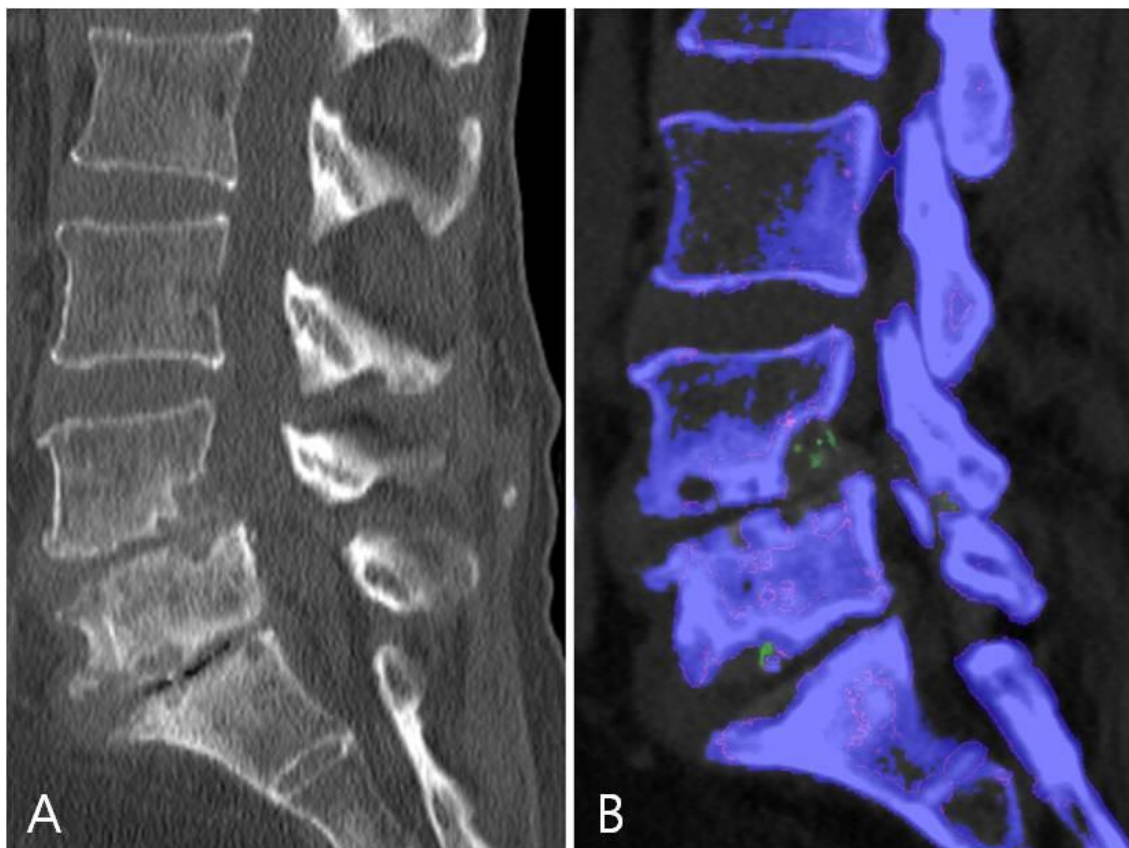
Lumbar spine computed tomography (CT) in axial gout. (A) Erosive changes in L4-5 and L5-S1 endplate on conventional CT. (B) Monosodium urate deposit (green) in the erosive foci of endplate on dual-energy CT.
